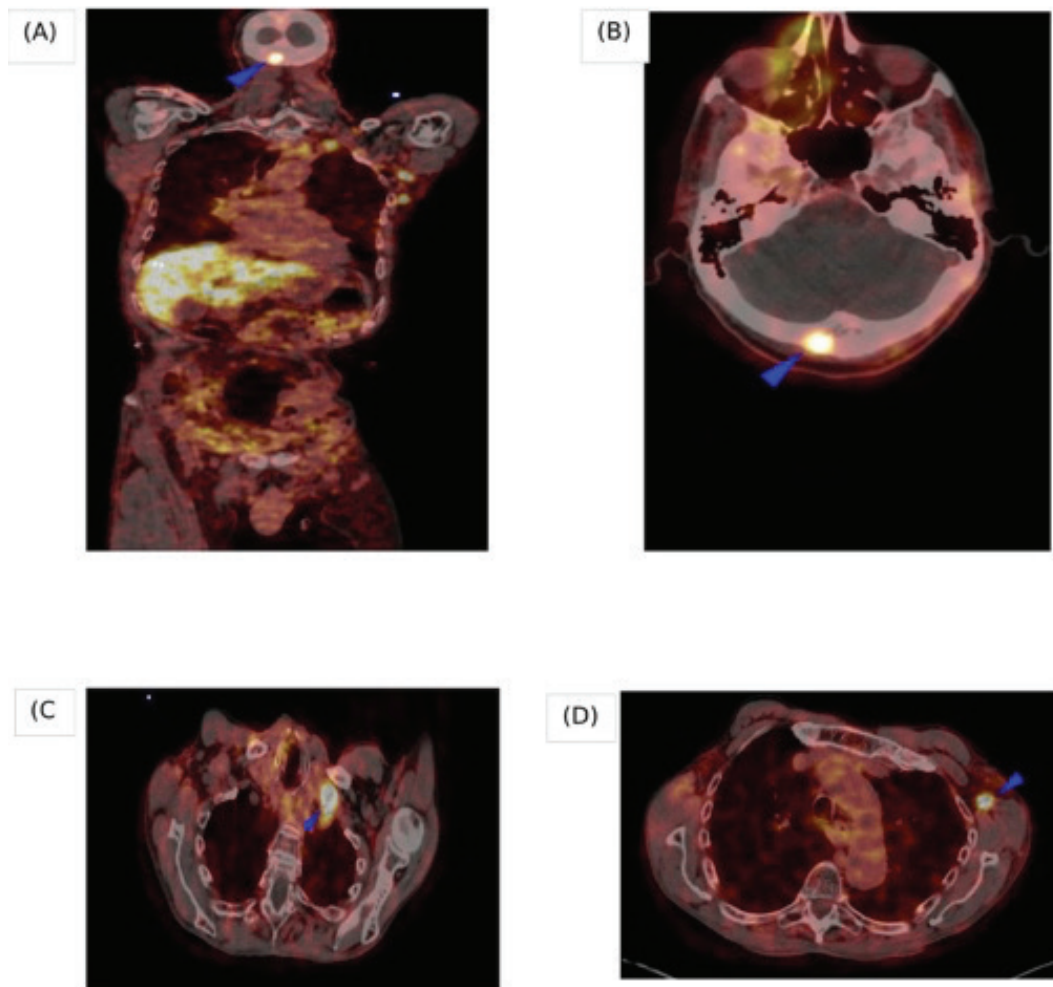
(A) Coronal fusion ^{68}Ga -PSMA PET/CT and (B) transaxial fusion PET/CT showed increased metabolic activity (SUV_{max} : 21.1) on the right side of the occipital bone (arrows), (C) on the left supraclavicular and (D) left axillary areas (arrows) (SUV_{max} : 13)
